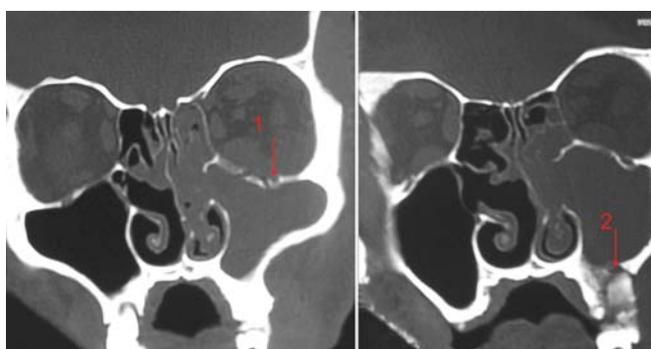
Coronal CT scan showing infected left maxillary sinus
